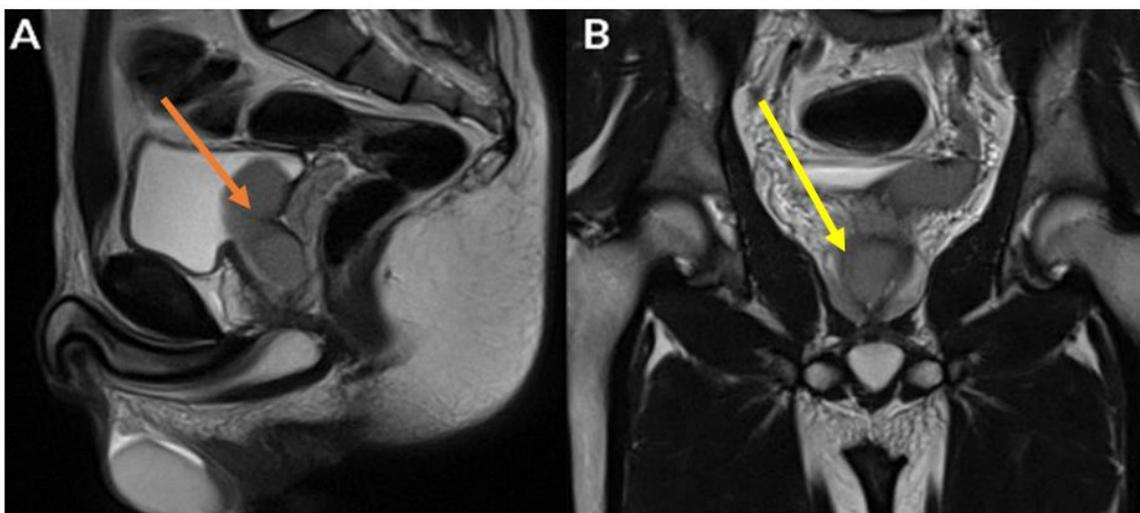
(A) T2 sagittal MRI cut: dilated left ejaculatory duct; (B) T2 sagittal MRI cut: obstruction of the right ejaculatory duct
